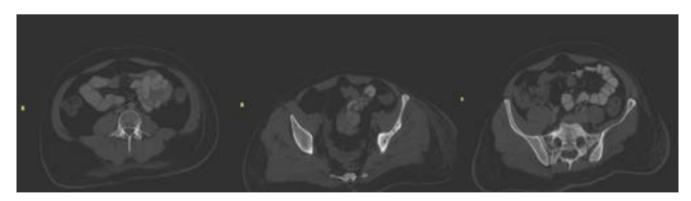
CT images showed Polka-dot sign or salt and paper appearance in T12, L1 and L3–L5 vertebrae, as well as lytic lesions in the sacrum and destructed left iliac bone
